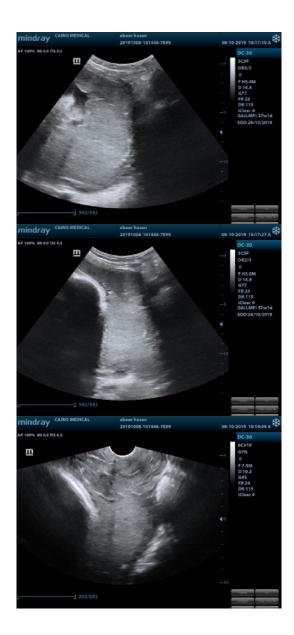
Ultrasound imaging of case 2
